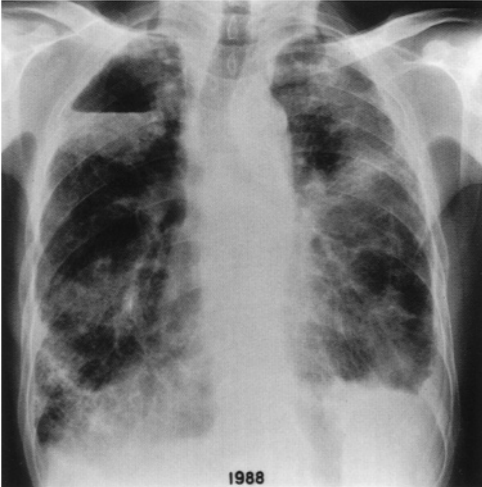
A PA chest radiograph reveals diffuse interstitial fibrosis and multiple large opacities in both lungs. A cavity with fluid level is noted in the right upper lung. The ILO classification is C, 2/2, t/t, cv, pt
